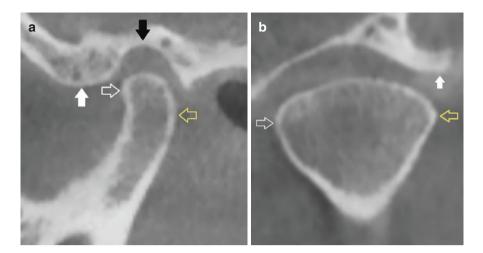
The osseous morphology of the TMJ as seen on CBCT axially corrected sagittal oblique (a) and coronal oblique (b) cross sections. The arrows point to important diagnostic landmarks that help the observer determine whether the condyle has normal contours or has been altered due to disease. On (a), the yellow hollow arrow points to the posterior height of contour, and the white hollow arrow points to the anterior height of contour of the condyle. The black solid arrow points to the roof of the fossa, and the white solid arrow points to the crest of the eminence. On (b), the white solid arrow points to the lateral rim of the fossa. The yellow and white hollow arrows point to the lateral and medial poles of the condyle, respectively
